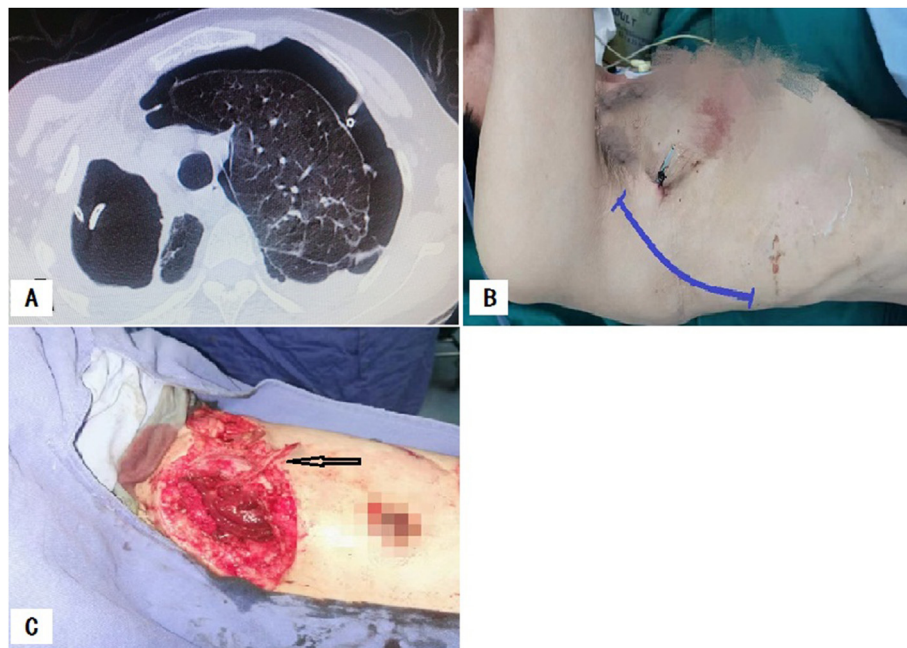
Preoperative and intraoperative images of case-1. A. The chest computed tomography at admission showed left pneumothorax and right hydro-pneumothorax with drainage tubes placed in the thoracic cavity on both sides. B. Design of chest incision before operation. C. The thoracodorsal vessels and nerves were completely separated along the anterior edge of latissimus dorsi.
